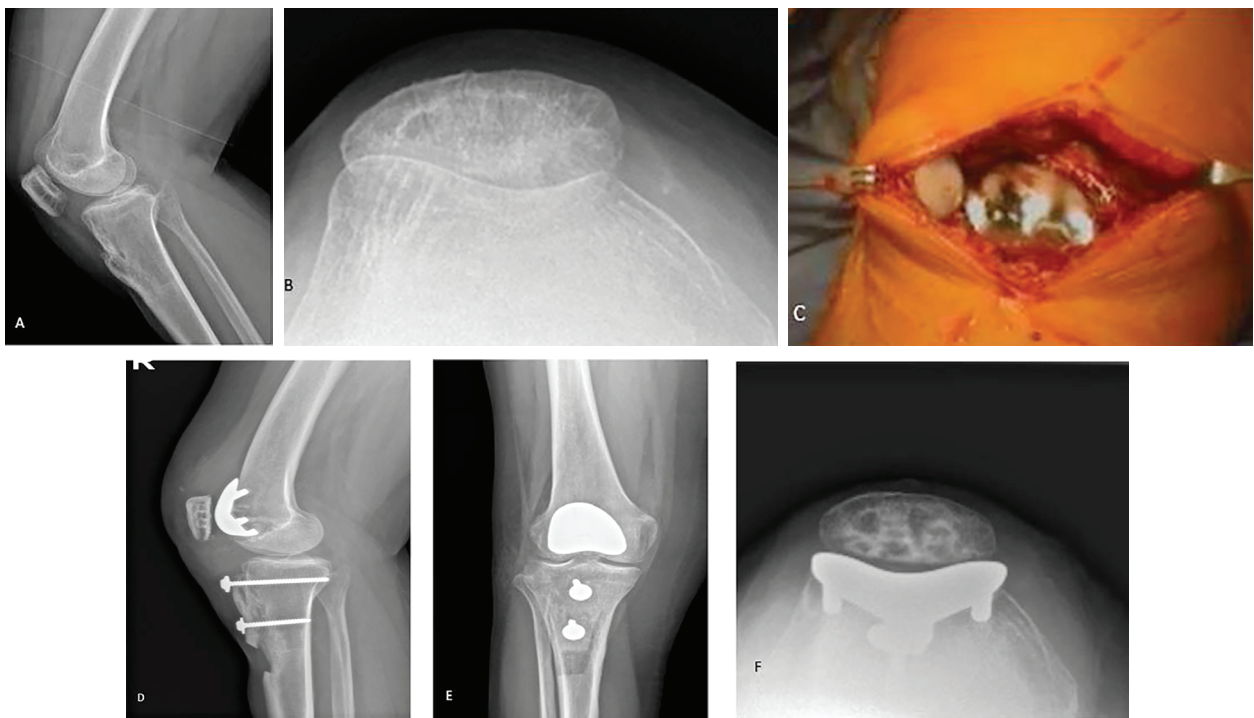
Patella baja following the transposition of the tibial tuberosity with chronic anterior knee pain (A,B). Implanted PF prosthesis (C). Postoperative radiographic image of the implanted PF prosthesis with proximalization of the tibial tuberosity (D,E,F)
